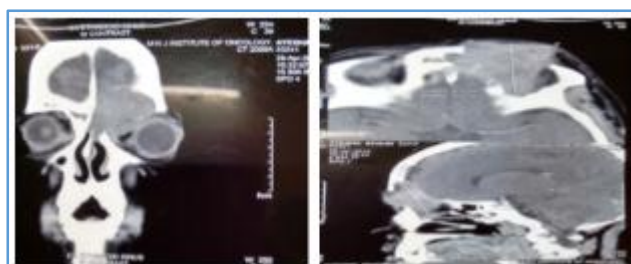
The CT scan: Anon-homogeneous soft tissue density occupying the frontal and Ethmoidal sinuses
